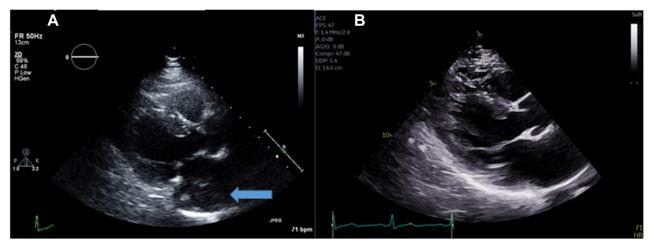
(A) Parasternal long-axis view with a noted subtle ill-defined echodensity located near the LA (*blue arrow*) performed as resting imaging at the time of exercise stress echocardiogram. (B) Similar parasternal long-axis view performed 1 year later as part of a comprehensive resting echocardiogram without evidence of the ill-defined echodensity.
